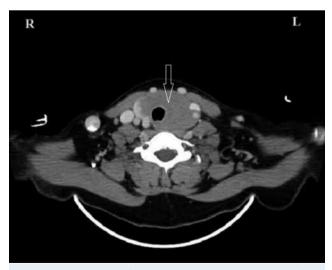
CT image of the mass located at the thyroidal lodge, before medical treatment
